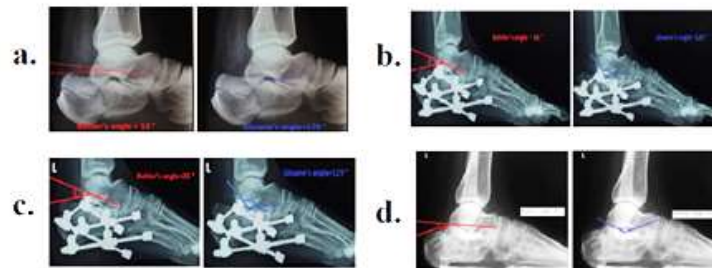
Radiograph showing Bohler’s and Gissane’s angle. a. Preoperative b. Immediate post-operative day 1 c. at 1 month follow-up d. at 12 months follow-up
